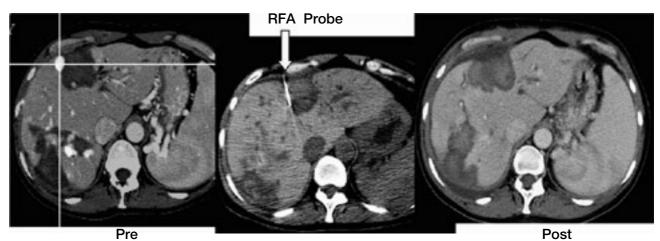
Fused CT and PET images guide precise radiofrequency probe placement for ablation. Similar methods may be used for biopsy needles to improve diagnostic yield. (Courtesy : Brad Wood, MD (NIH))
